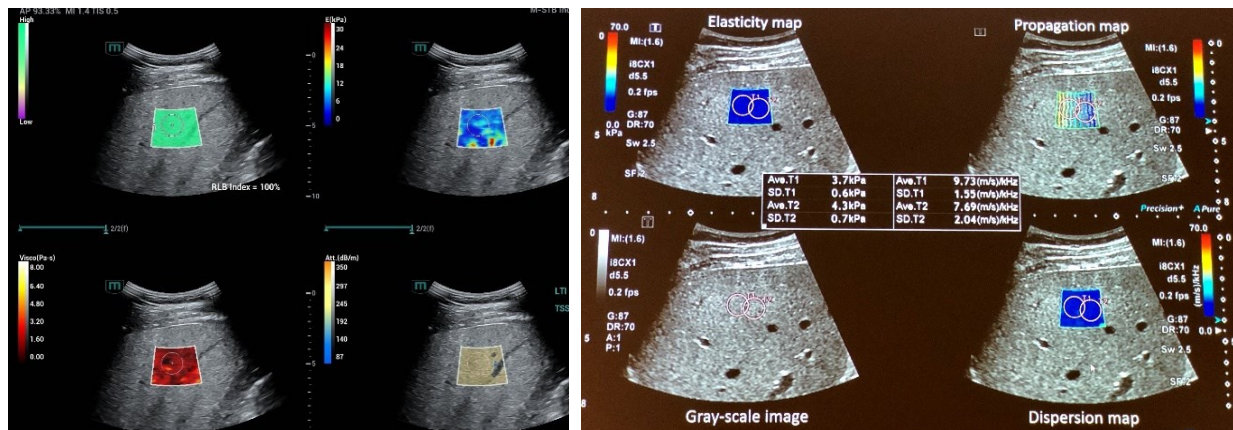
A-B. Multiparametric Ultrasound (MPUS) for Liver Evaluation. These images demonstrate an integrated approach that combines shear wave elastography, attenuation measurement, backscatter analysis, and dispersion mapping to provide a comprehensive assessment of the liver parenchyma.
